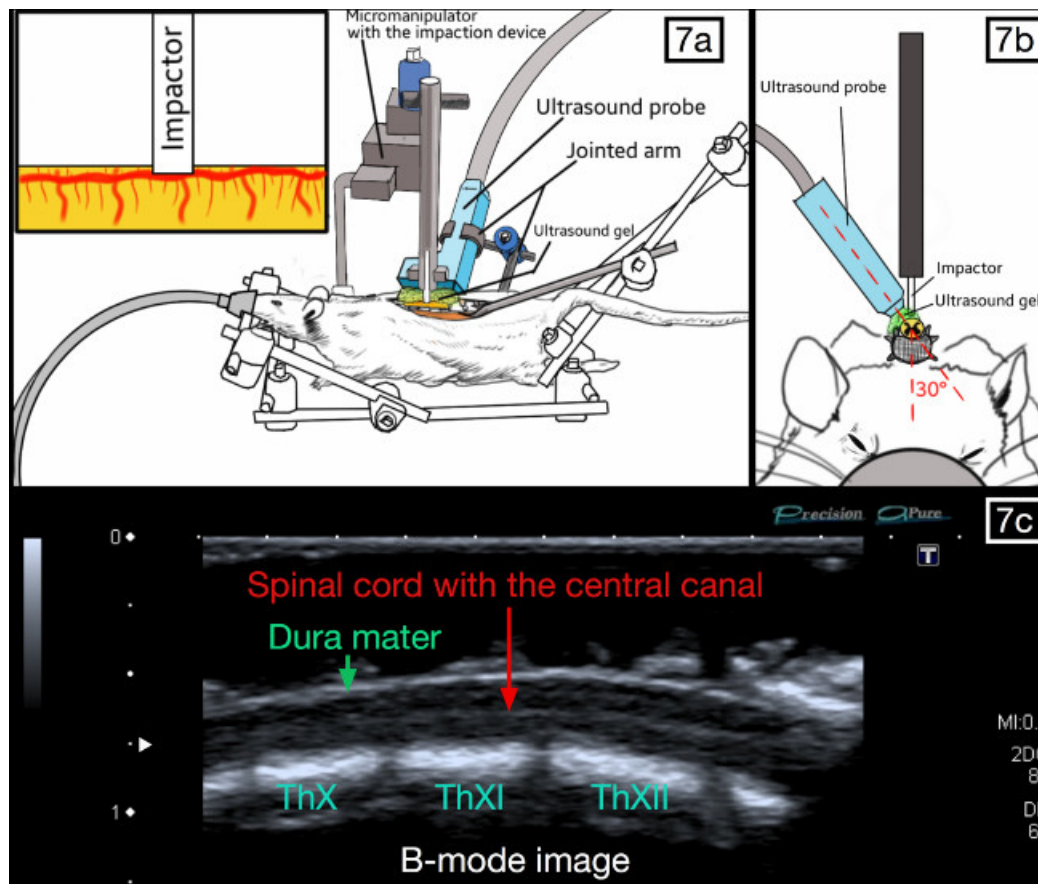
Positioning of the ultrasound probe and the impaction device. The probe is parallel to the spinal cord and slightly oblique (20-30°), so that the weight-drop impactor can be placed against the posterior aspect of the dura. The spinal cord should be visible with the central canal present throughout the middle segment on the ultrasound imaging “B-Mode”. [Please click here to view a larger version of this figure.](#)
